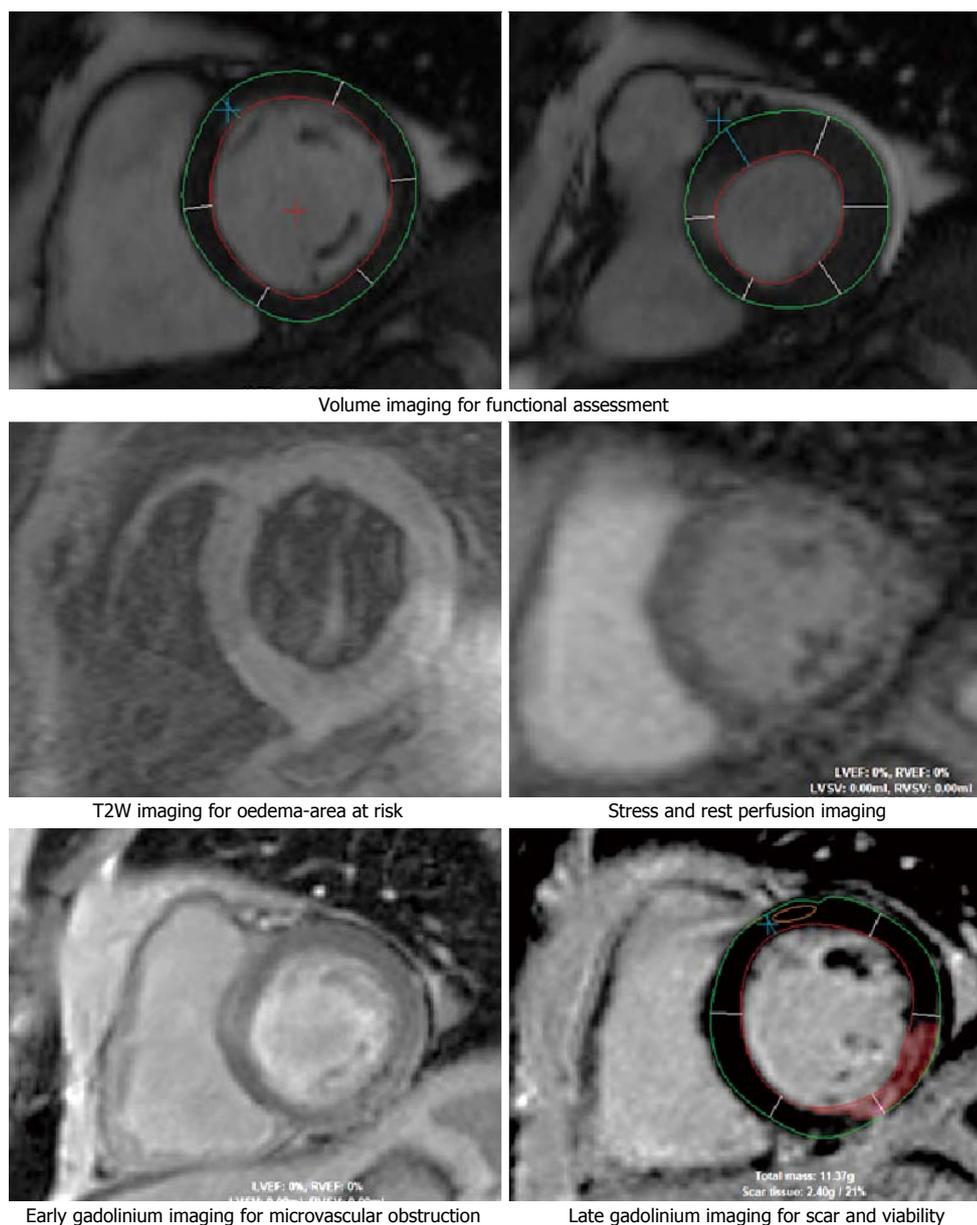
Cardiovascular magnetic resonance imaging sequence employed for the diagnosis of acute coronary syndrome. T2W: T2-weighted.
